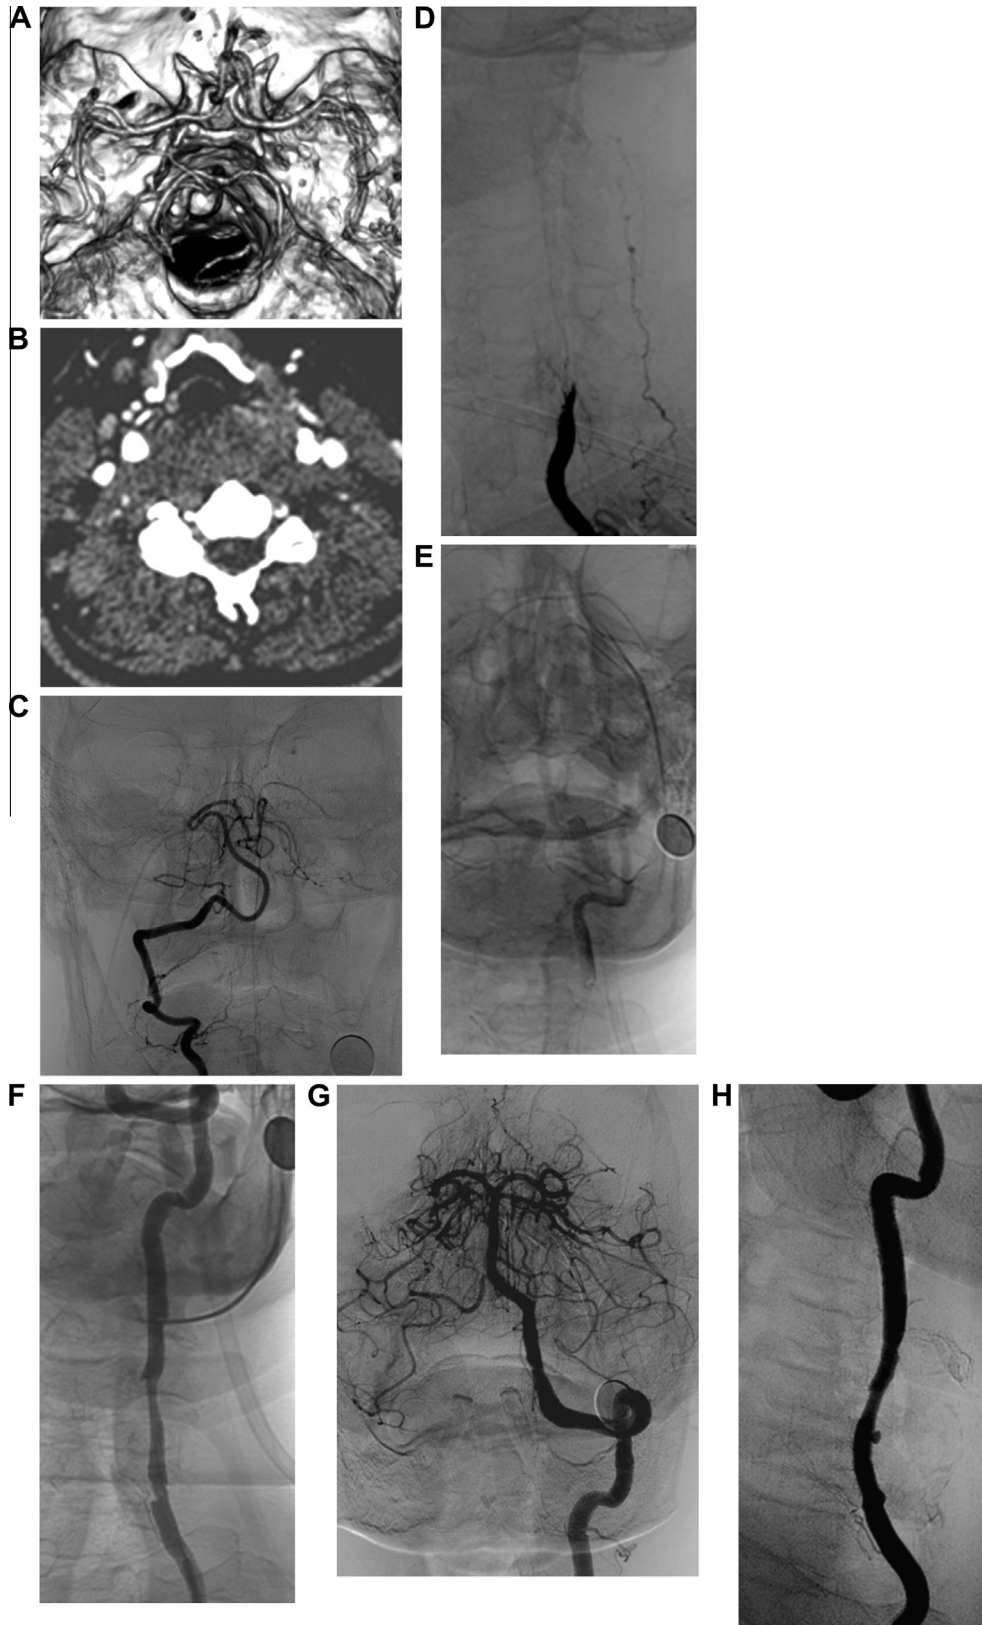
(A) CT angiography reconstruction of intracranial arteries showing an incomplete circle of Willis (no posterior communicating arteries anastomose anterior to posterior circulations). (B) CT angiography of the cervical arteries showing a hypoplastic right vertebral artery and severe dissection of the dominant left vertebral artery. (C) Right vertebral artery angiogram showing the hypoplastic vertebral artery ending at the posterior inferior communicating artery. Only a faint collateral opacification of the basilar artery is insinuated. (D) Left vertebral artery angiogram demonstrating complete occlusion of the proximal dominant artery (V2 segment). (E) Vertebral artery occlusion is crossed with a microcatheter. Microangiogram identifies the uninjured true lumen beyond clots complicating the dissection and causing complete occlusion. (F) Left vertebral artery angiogram showing the repaired arterial segment immediately after applying low-pressure angioplasty over the implanted diverter. (G) Left vertebral artery angiogram obtained immediately after recanalization showing restitution of the normal vertebrobasilar circulation. (H) Follow up angiogram obtained after 3 months showing the repaired arterial segment.
